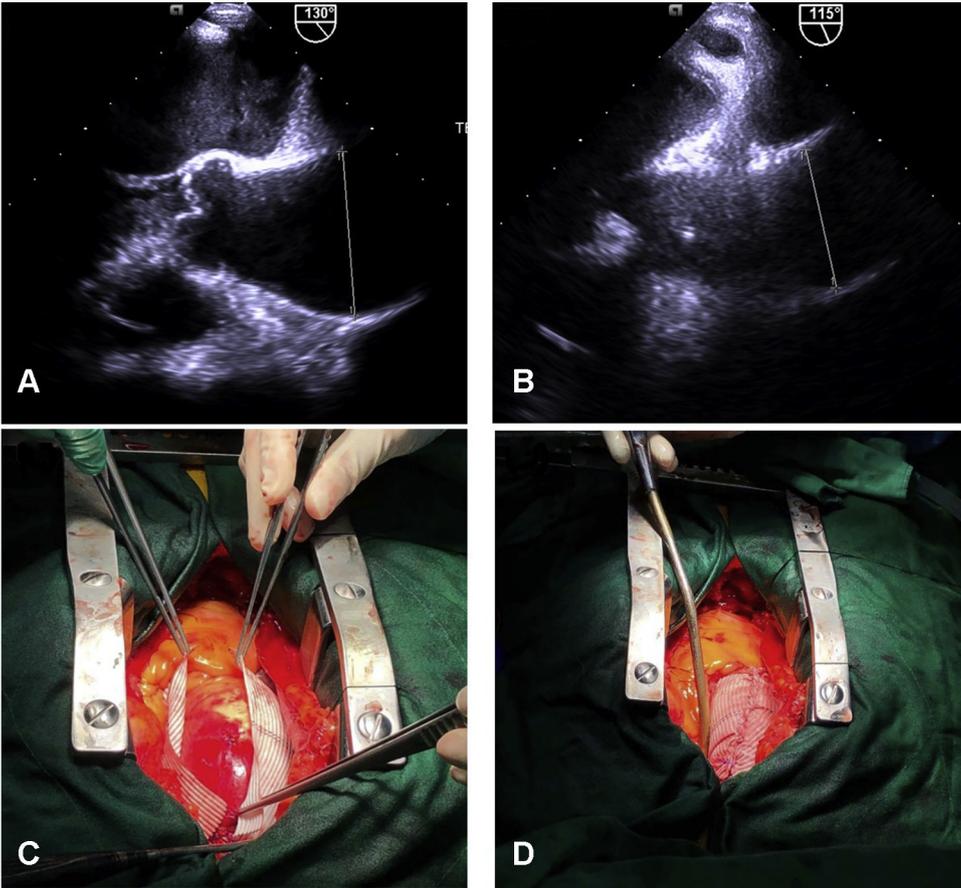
Intraoperative transesophageal echocardiography before (A) and after (B) AAW. The real filed pictures before (C) and after (D) AAW.
